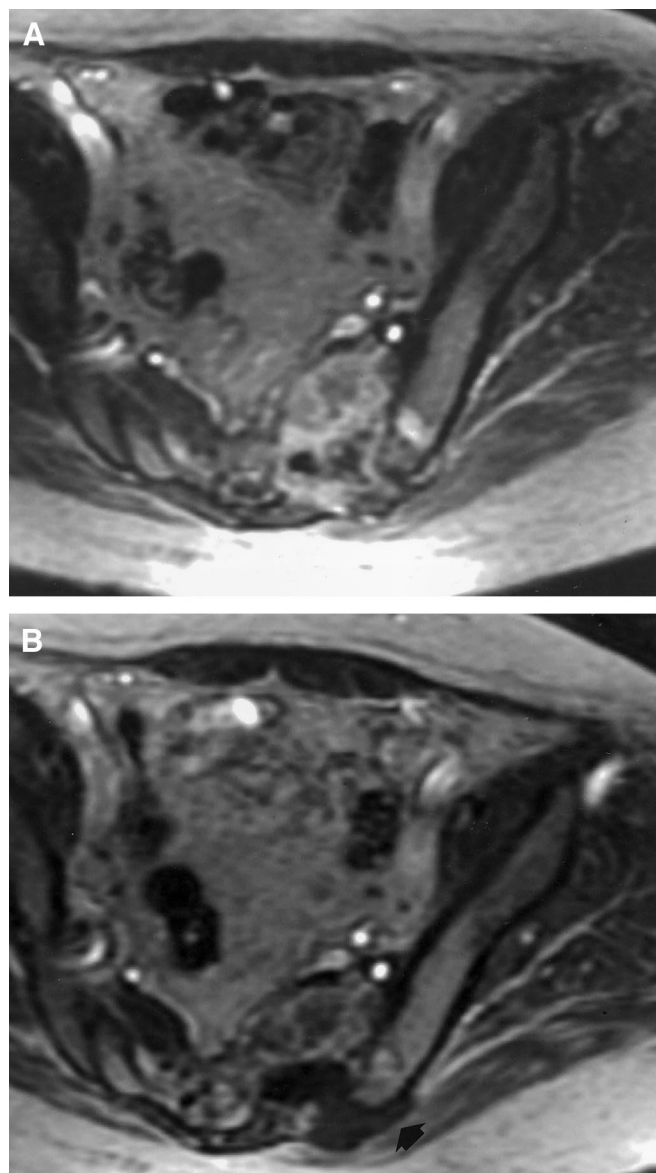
Dynamic contrast-enhanced magnetic resonance images showing a decline in perfusion of a sacral metastasis in a patient with papillary thyroid cancer. Delayed postgadolinium T1-weighted images (A) before and (B) 1 week after CA4P treatment. In B, note the absence of enhancement in the inferior portion of the tumor (arrow).
